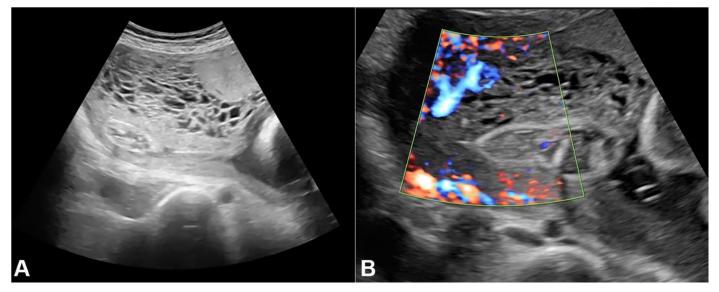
Ultrasound showing placenta with the cystic area.
